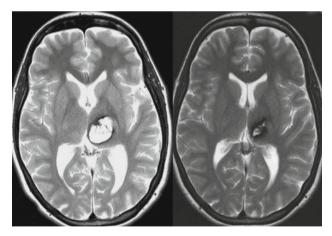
T2-weighted axial MRI (*left*) showing a significant hemorrhagic lesion most likely caused by a cavernous malformation within the left posterior thalamus that has caused a contralateral sensory disturbance. Six months later the symptoms had disappeared and control MRI (*right*) demonstrates that the haematoma had been completely resorbed. Apart from residual haemosiderin deposits, no active cavernous malformation can be detected; there is no indication for surgical exploration in this case
